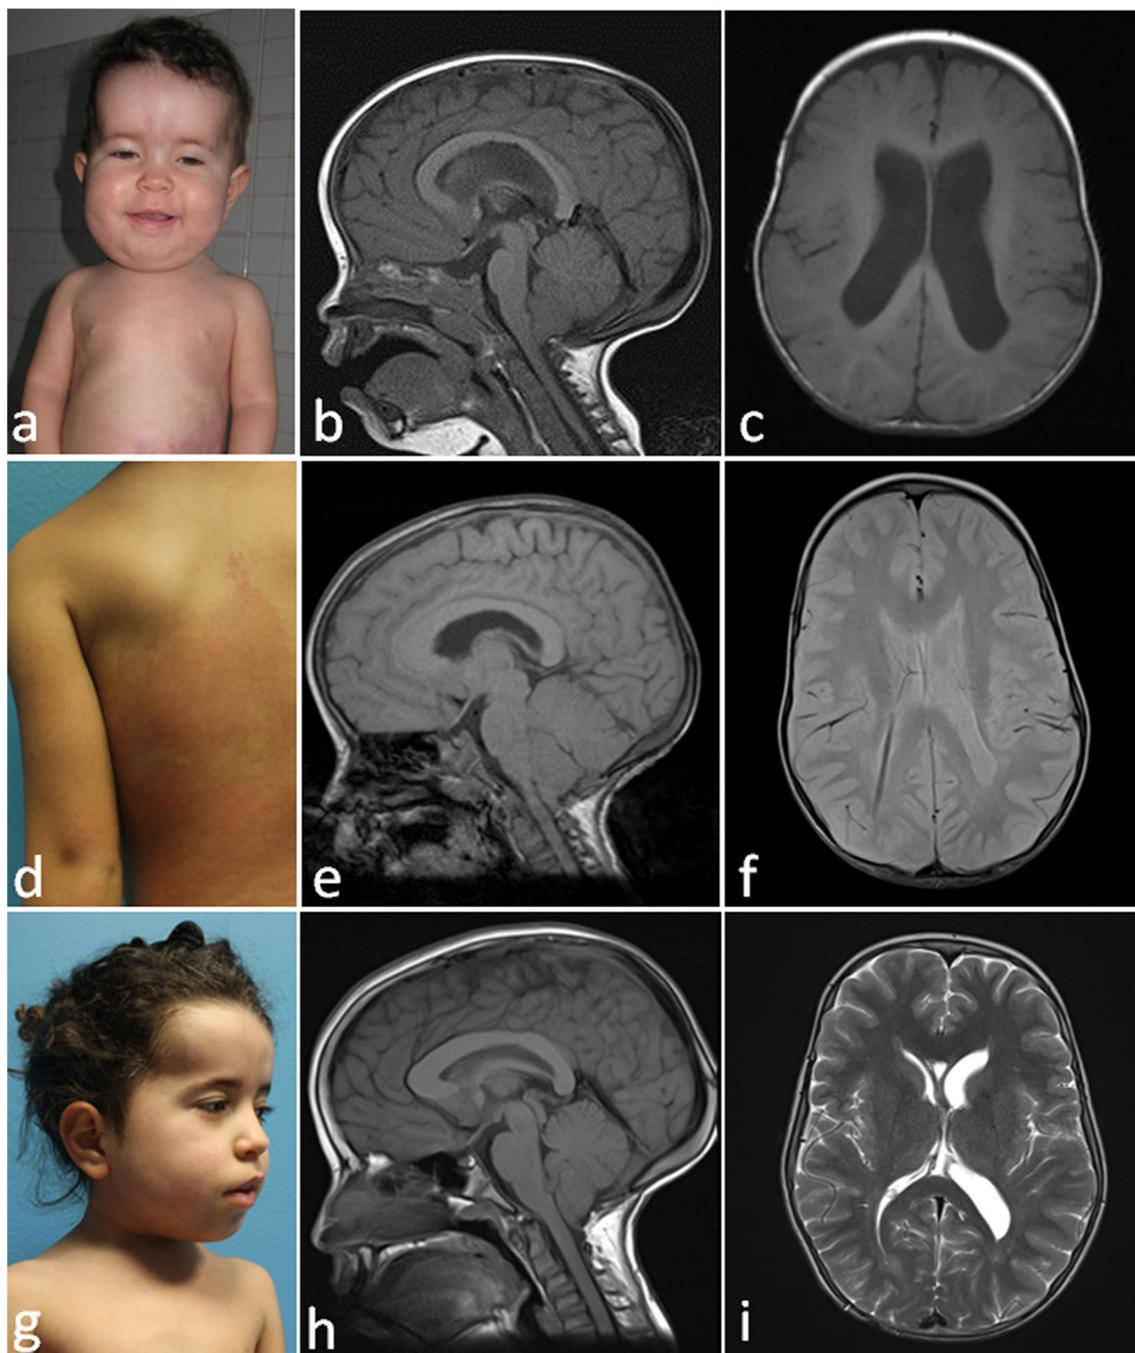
Phenotypic and radiological evolution of a girl with MCAP. a shows the girl at the age of 12 months with the corresponding sagittal and axial T1-weighted MRI scans in b and c. Megalencephaly is visible as well as CMI. In d, detail of dorsal region of the child at 24 months of age with the typical cutaneous capillary malformation. The sagittal (e) and axial (f) MRI scans performed at that age, six months after ventricular
